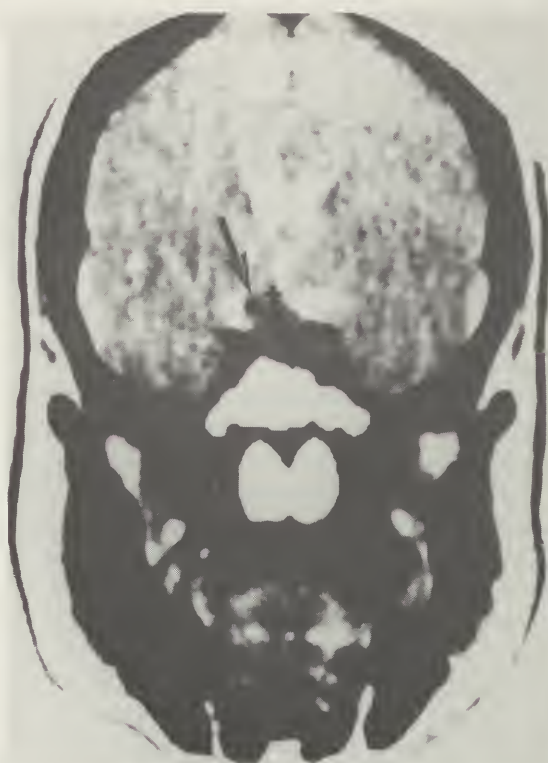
CT scan with contrast showing pituitary tumor with suprasellar extension prior to transsphenoidal removal. Arrow points to suprasellar extension.
